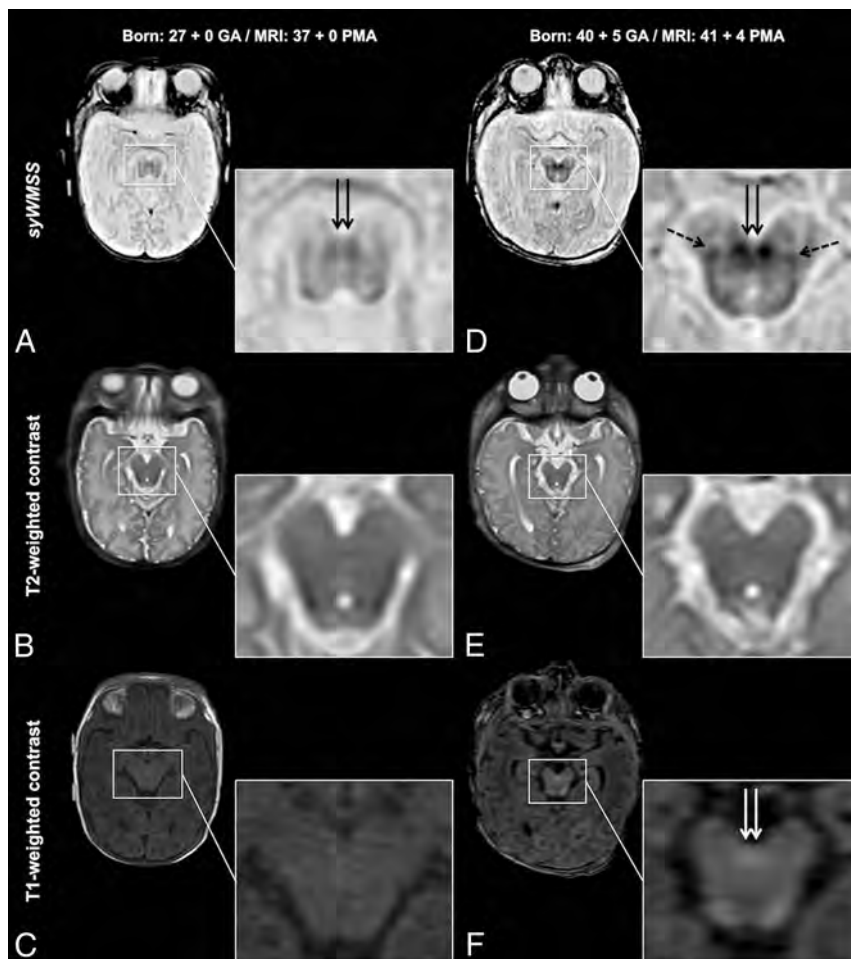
Myelin-related signal intensity differences between preterm-born neonates and term-born infants are demonstrated. The midbrain is shown in a neonate born at 27 + 0 weeks' GA (MR imaging at 37 + 0 weeks postmenstrual age) (A, B, and C) and an infant born at 40 + 5 weeks' GA (MR imaging at 41 + 4 weeks postmenstrual age) (D, E, and F) on syWMSS data (A and D), conventional T2-weighted contrasts (B and E), and conventional T1-weighted contrasts (C and F). While proceeding myelination is perceivable on conventional T1-weighted MR contrasts (DSCP, double arrows in F), the information provided by conventional T2-weighted MR imaging contrasts regarding myelin-related signal alterations is limited. In contrast to standard-of-reference MR imaging acquisitions, WM signal suppression enables a reliable identification and assessment of progressively myelinating structures in the course of brain development (DSCP, double arrows in A and D and ML, dotted arrows in D). Center/width at the default setting.
